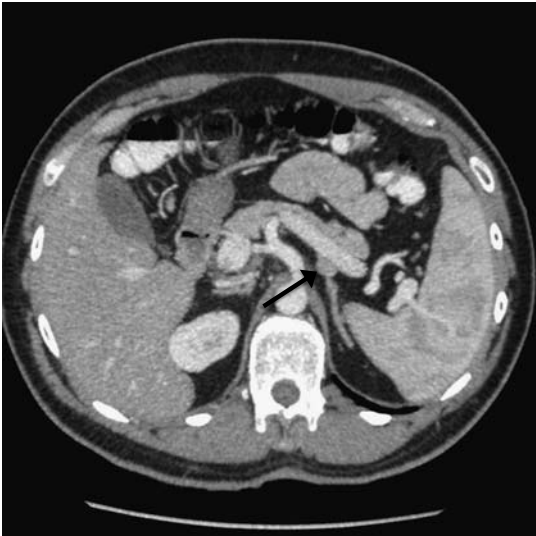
The CT abdomen revealed a 12-mm hypointense exophytic nodule arising from the posterior pancreatic body (arrow). No other parenchymal lesions were visualized.
